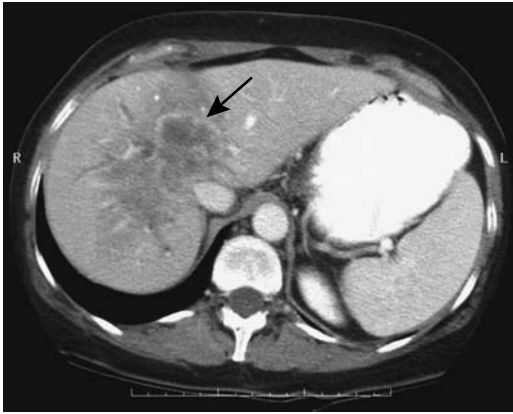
Intrahepatic cholangiocarcinoma. Contrast-enhanced CT identifies a poorly marginated tumor containing regions of necrosis (arrow). Dilated bile ducts are present in the medial segment of the left lobe and the right lobe. (Courtesy of Patrick Fultz, M.D., University of Rochester.)
